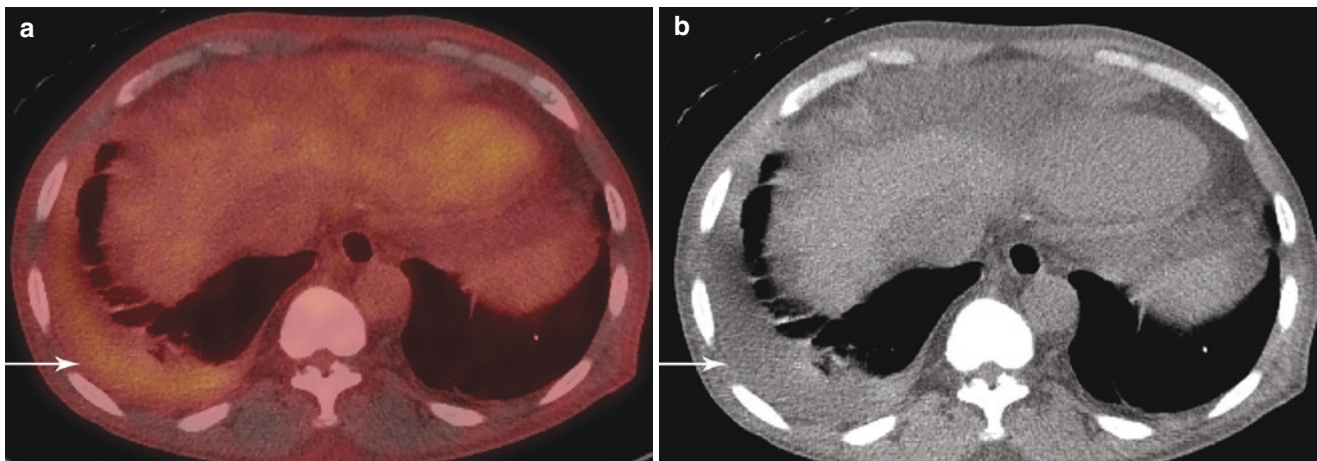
Primary effusion lymphoma in a patient with human herpes virus 8 infection. (a, b) Axial FDG PET/CT and non-contrast axial CT show a small right pleural effusion with FDG uptake similar to that of the liver with SUV of 2.6. There was no evidence of peritoneal involvement
